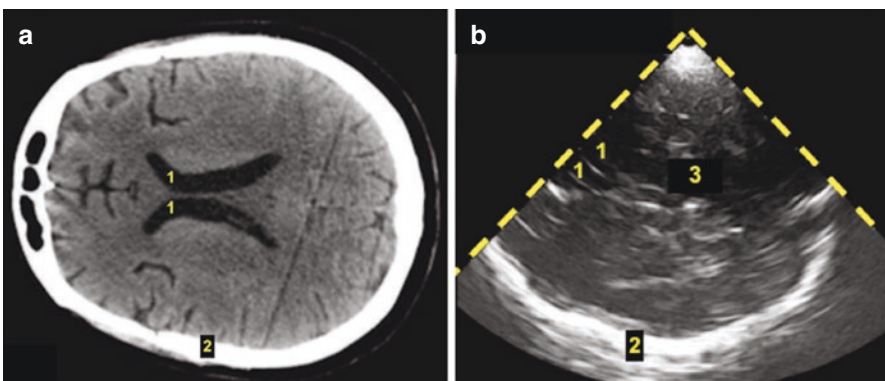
Lateral ventricles: (a) Computed tomography (CT): (1) Frontal horns of lateral ventricles, (2) Skull bone; (b) TCCS: (1) Frontal horns of lateral ventricles are visualized as hypoechoic structure. The three parallel lines correspond to lateral layers of ependima and septum pellucidum, (2) Contralateral skull bone and (3) Third ventricle
